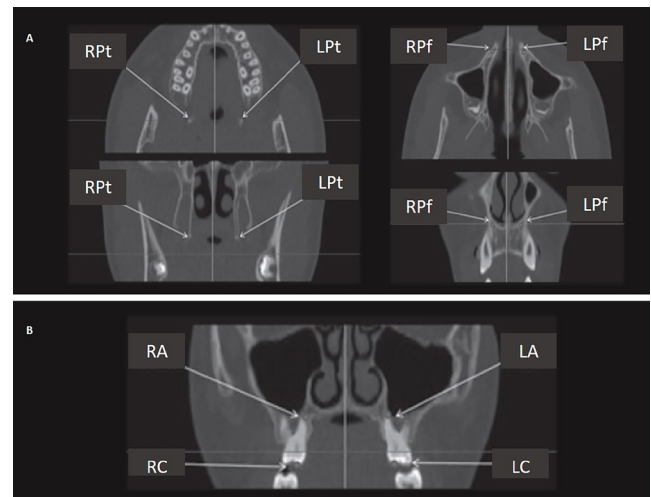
Landmarks determined on cone-beam computed tomography (CBCT) images
